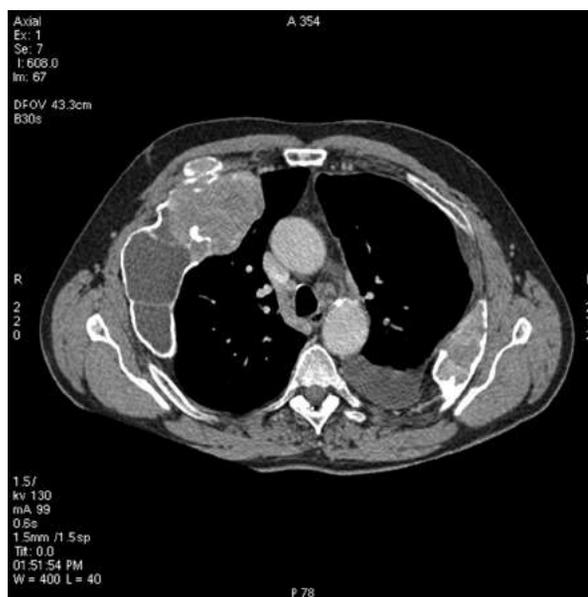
Computed tomography shows multiple osteolytic ribs, sternum and vertebral body lesions
